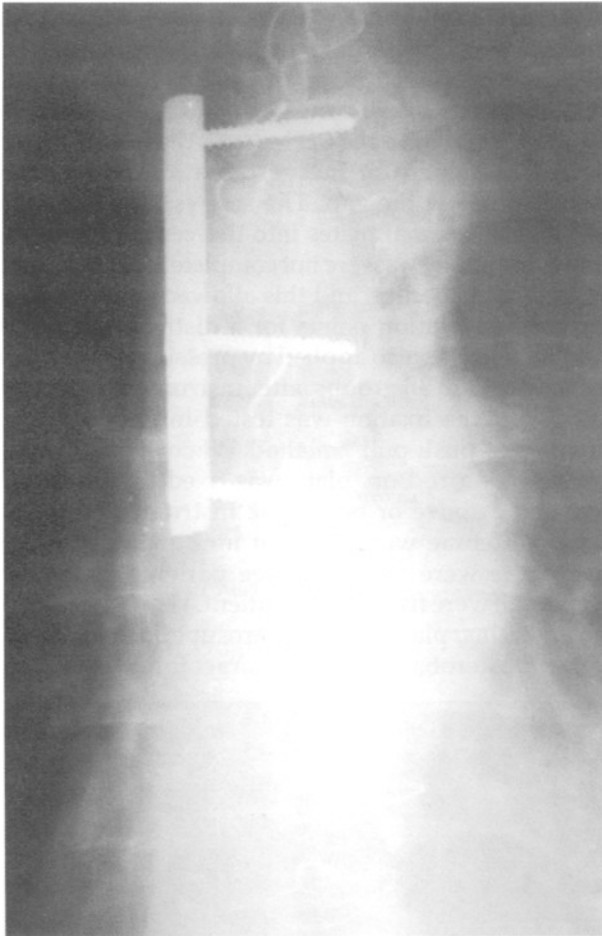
Anteroposterior x-ray film 9 months after surgery shows SVBS-plate fixation.
